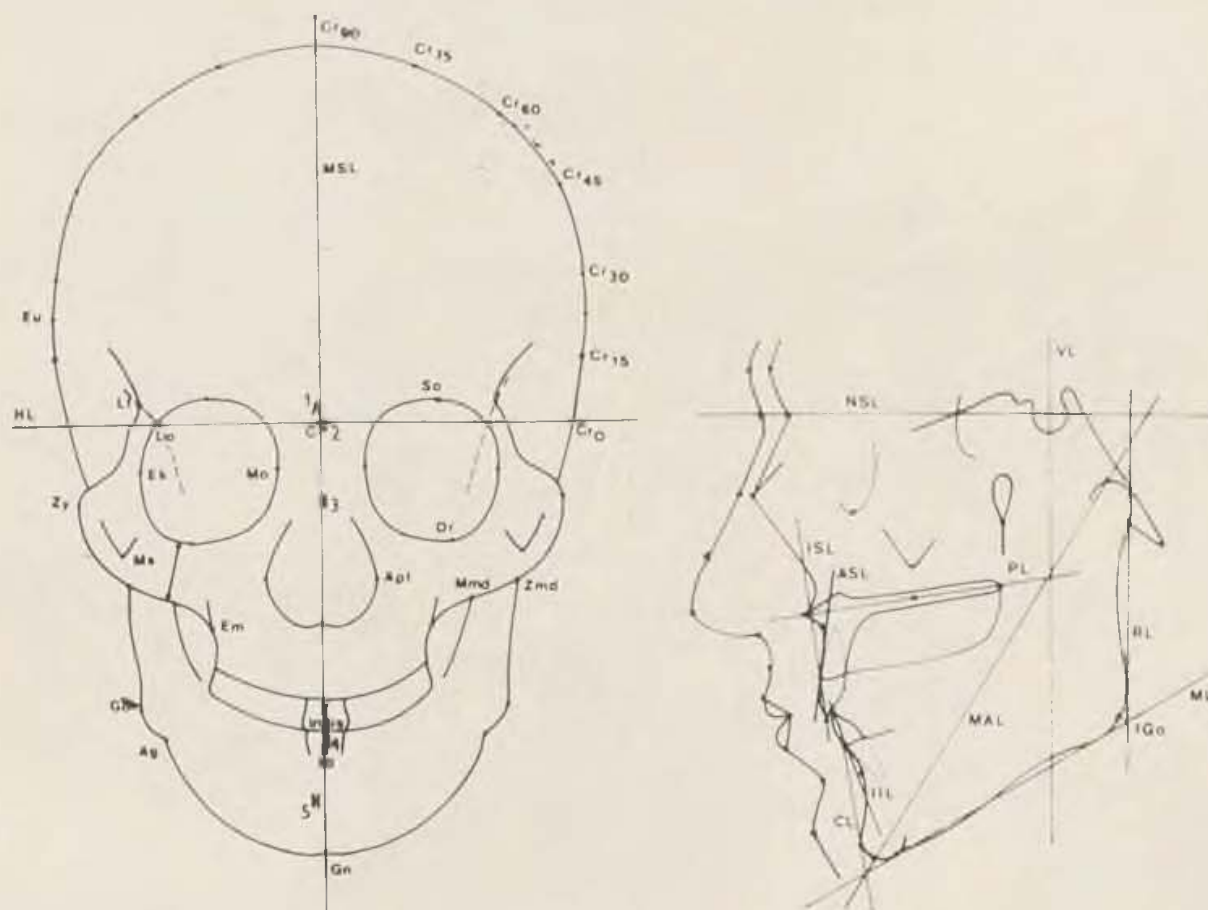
Craniometric points on anteroposterior X-ray films (dimension zy-max — arrow below the orbita)
